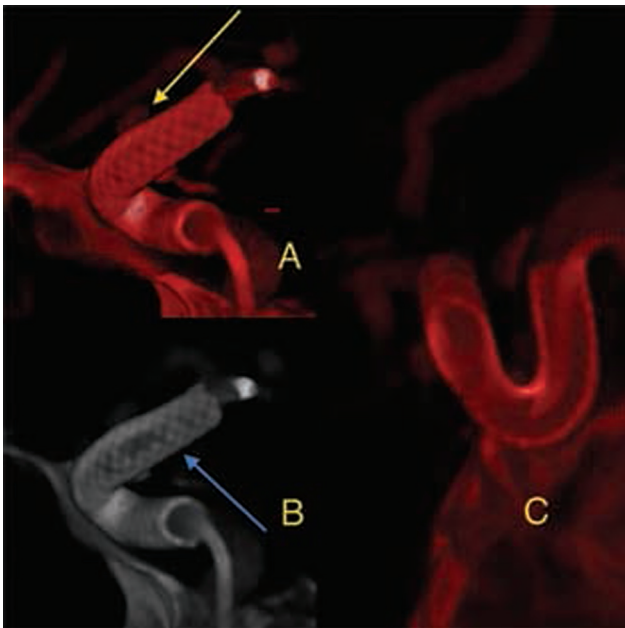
Intraarterial Vaso computed tomography images (A-C). (A) Yellow arrow denotes the blister aneurysm. (B) Blue arrow denotes deployed flow diverter. (C) Three-dimensional virtual longitudinal sectioning of the device depicting wall conformation.
